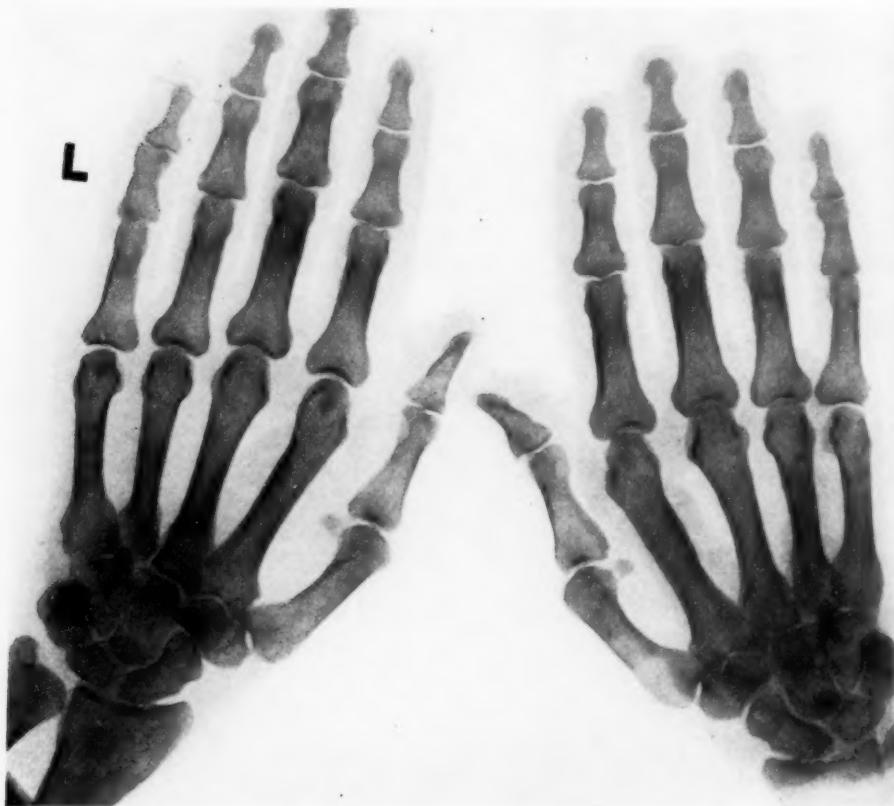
Roentgenograms of hands.
